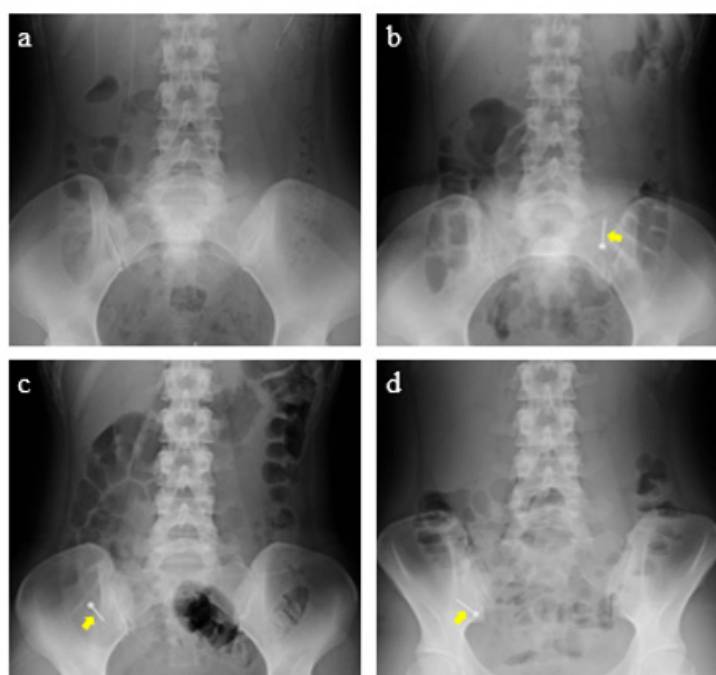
Abdominal X-ray.
